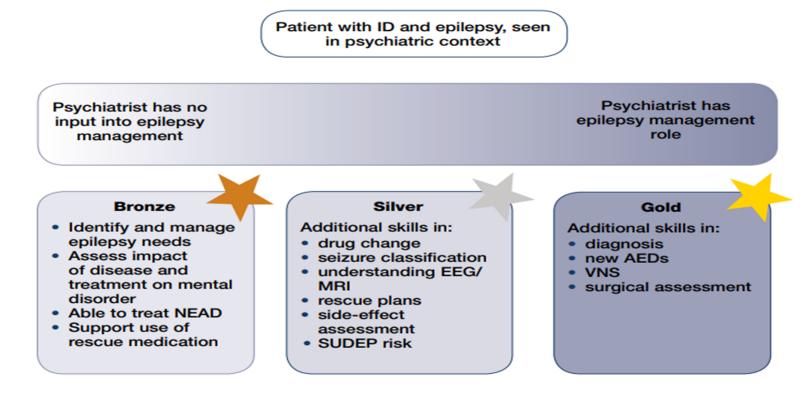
The psychiatrist's role in epilepsy service delivery. AED, anti-epileptic drugs; EEG, electroencephalogram; ID, intellectual disability; MRI, magnetic resonance imaging; NEAD, non-epileptic attack disorder; SUDEP, sudden unexpected death in epilepsy; VNS, vagus nerve surgery. Figure adapted with permission from *Epilepsy in People with ID: Can we Reduce the Burden of Disease?* Keynote presentation by Professor Mike Kerr at the Faculty of Psychiatry of Intellectual Disability Annual Conference, 26–27 September 2013.
